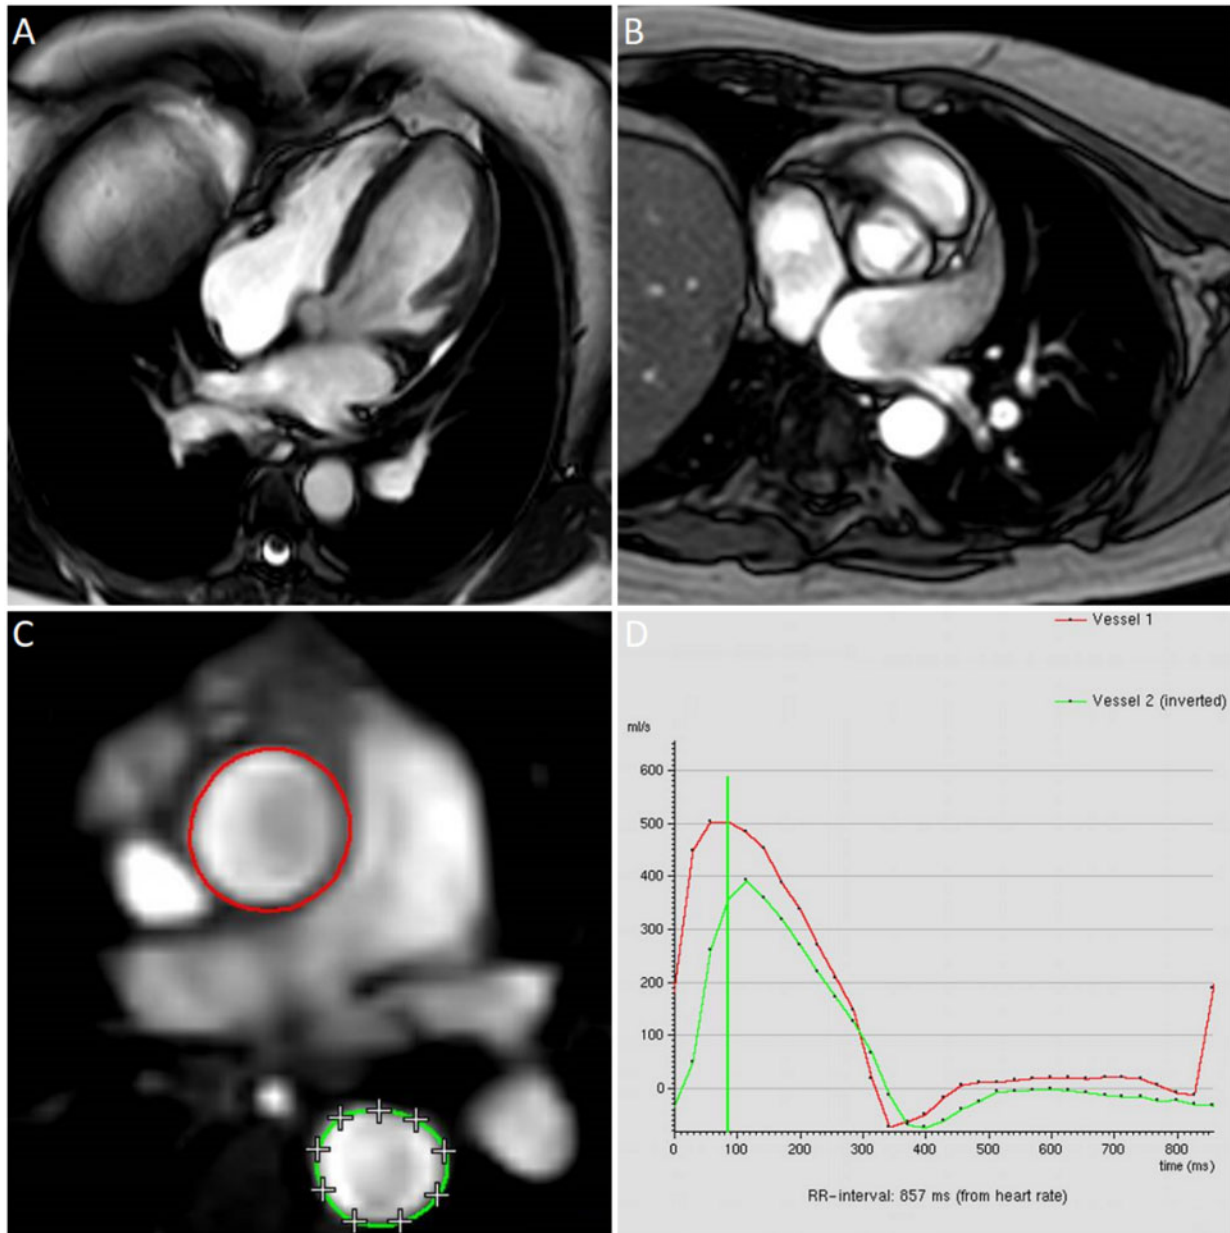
Cardiac magnetic resonance imaging revealed a mild to moderate aortic regurgitation in a tricuspid aortic valve, and a mildly dilated left ventricle with a normal systolic function (left ventricular ejection fraction 66%). (A) The aortic regurgitant jet visualized in the five-chamber view. (B) Short-axis view showed a tricuspid aortic valve. (C) Region of interests for antegrade flow in the ascending aorta (red) and retrograde flow in the descending aorta (green). (D) Flow-vs.-time plot in the ascending aorta with a calculated antegrade flow of 113 mL/beat and a retrograde flow of 34 mL/beat, and aortic regurgitant fraction 30%.
